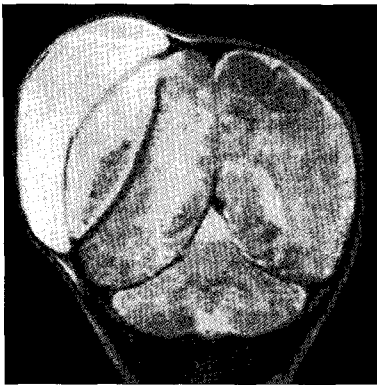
Magnetic resonance images showing the massive crescent-shaped cephalohematoma and epidural hematoma over the right temporoparietal region with the skull fracture. A tense scalp pouch over the fracture was filled with a subacute hematoma and communicated to the epidural space through the skull fracture. The epidural hematoma contained some mixed signals.
